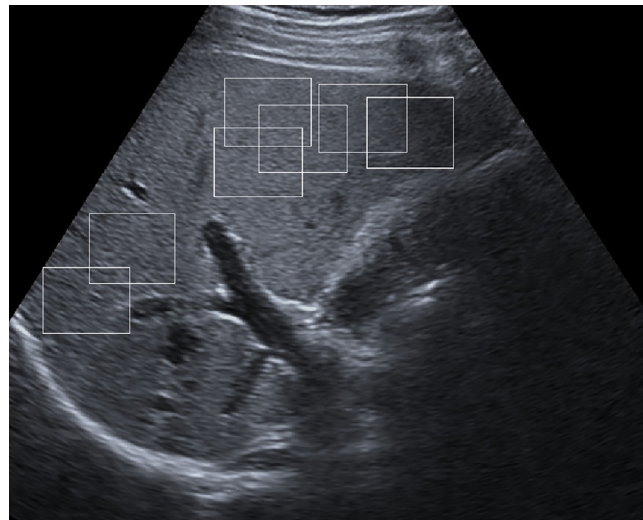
Liver ultrasound image. Rectangular boxes in the image represents the texture used for classification.
